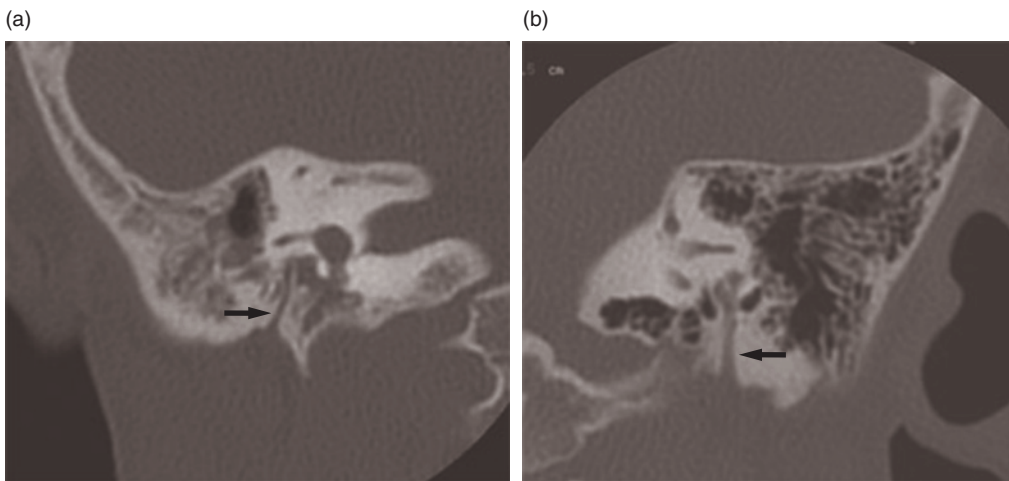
Coronal CT images. (a) Right atresia and anterior dislocation of the mastoid segment of the facial nerve (arrow); (b) normal situation of the nerve on the left (arrow) (reproduced from Calzolari F., 2006,⁶ with permission of Omega Edizioni).
